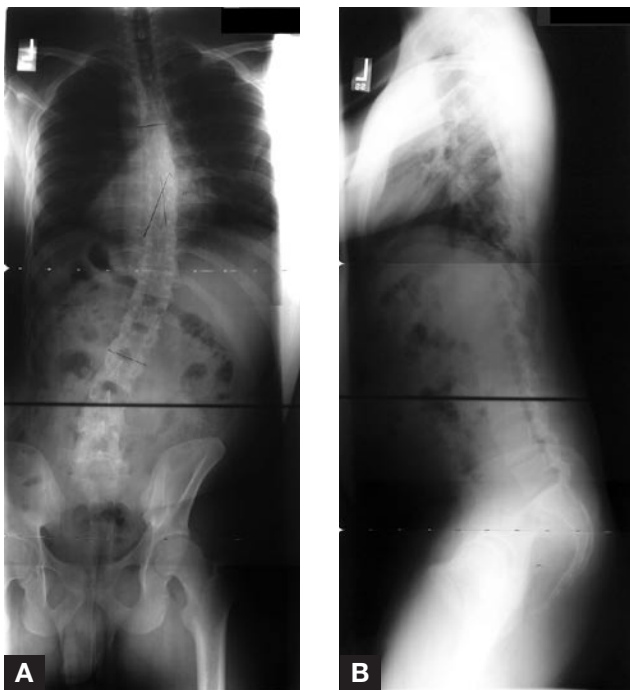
Preoperative radiographs: (A) Anteroposterior view shows thoracolumbar scoliosis with convexity to right measuring 30°; (B) lateral view shows decreased lumbar spinal lordosis with a forward tilt of torso.
